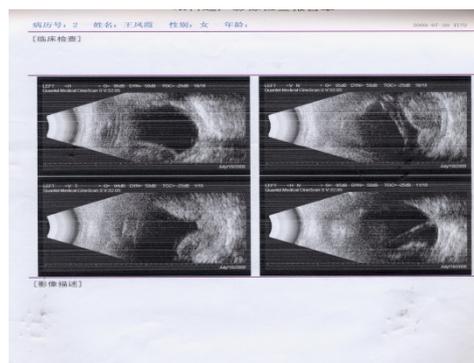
Ocular ultrasonography displayed the detachment of the retina and choroid.
